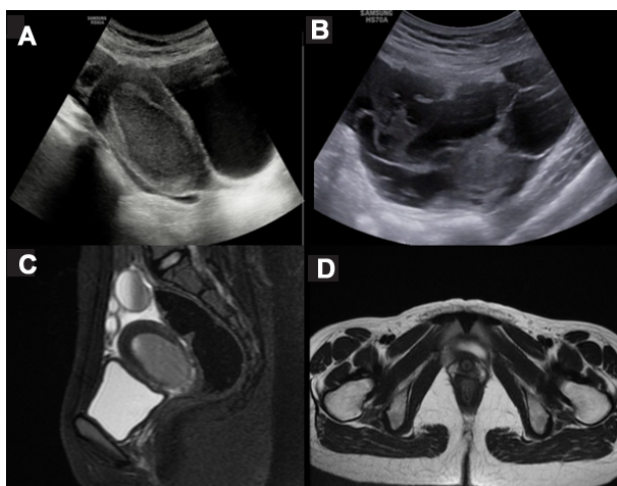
Transabdominal Ultrasound (A, B) and MRI Pelvis (C, D) demonstrating Cervico-vaginal aplasia with hematocolpos
